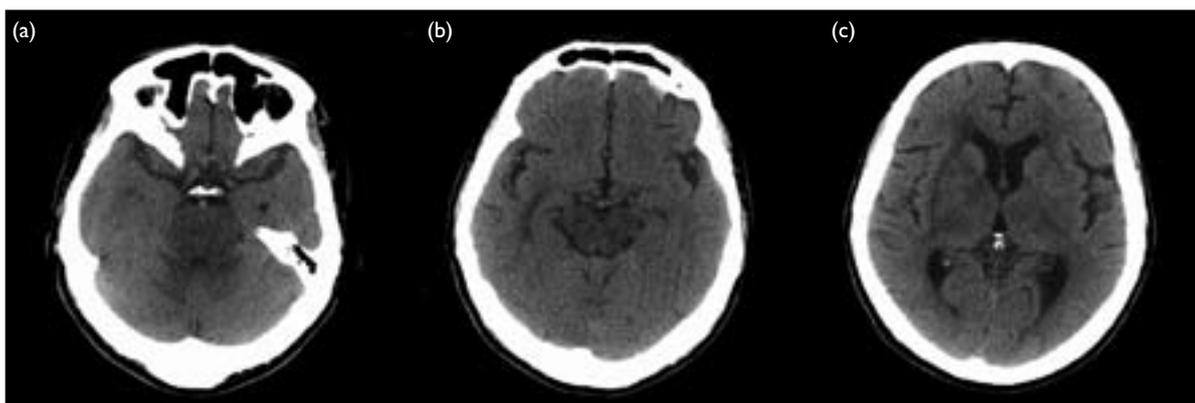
Initial computed tomographic scans of the brain at pons, midbrain and occipital lobe levels show diffuse hypodensity in the pons (a), midbrain (b), and periventricular white matter (c) with sparing of the occipital lobes
